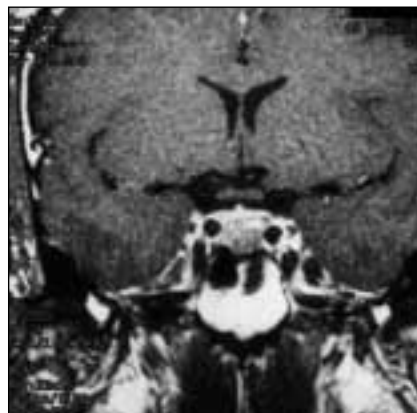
Midline coronal section of postcontrast MRI of head demonstrating no enhancement of pituitary adenoma.
